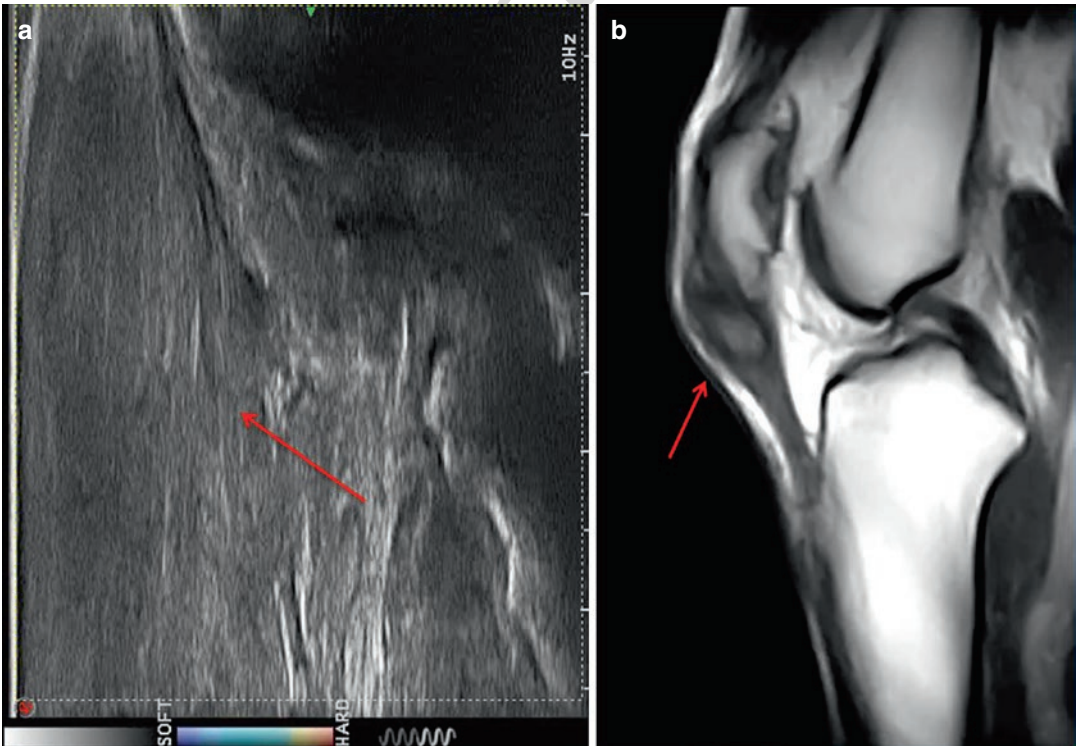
(a, b) Severe tendinopathy involving the proximal insertion of the patellar tendon in a patient with jumper's knee documented by dynamic elastography and MRI
